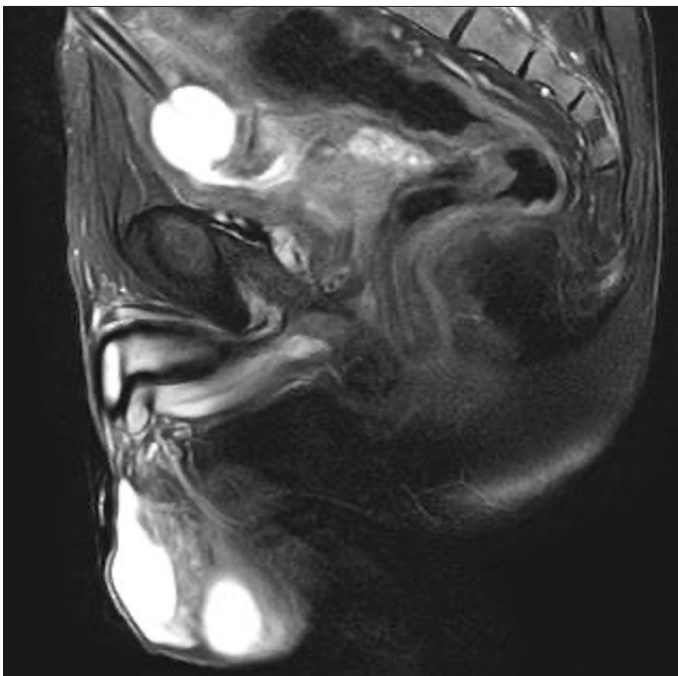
Magnetic resonance imaging (MRI) with empty bladder
